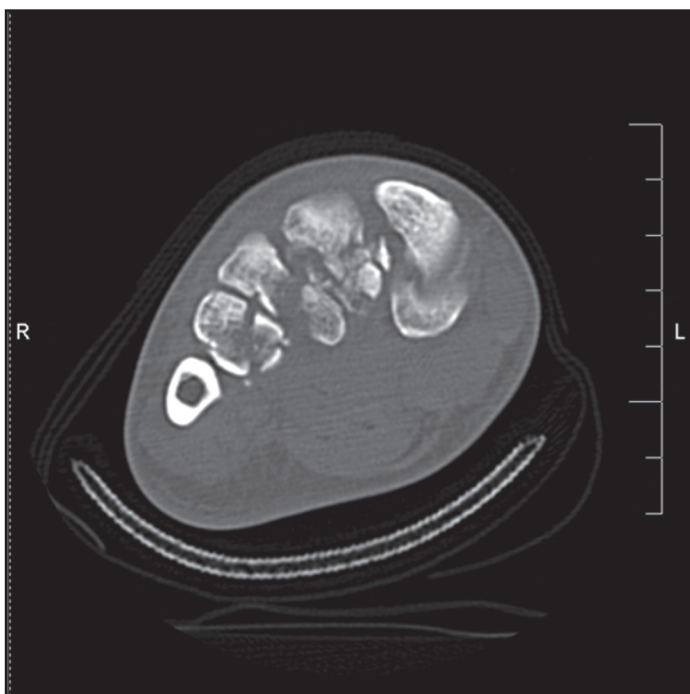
A Conventional CT Coronal Reconstruction through the Tarsometatarsal Region. The fracture lines are clearly delineated and the extent of displacement of the fracture fragments is revealed in this image.
